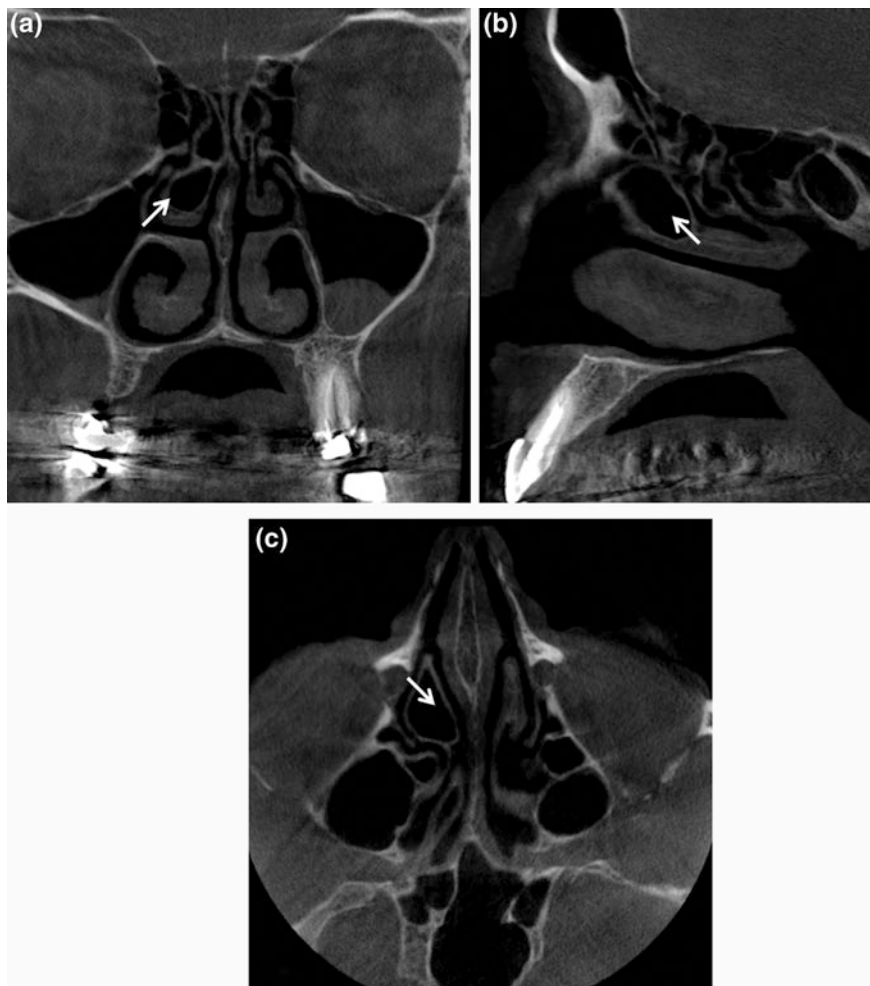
CBCT coronal (a), sagittal (b) and axial (c) sections showing the pneumatisation of the right middle turbinate also known as concha bullosa (*thin arrow*) which can potentially narrow the middle meatus. Note that there is preservation of the air channel between the concha and the nasal septum. Severe deviation of the nasal septum with double curve can be seen
